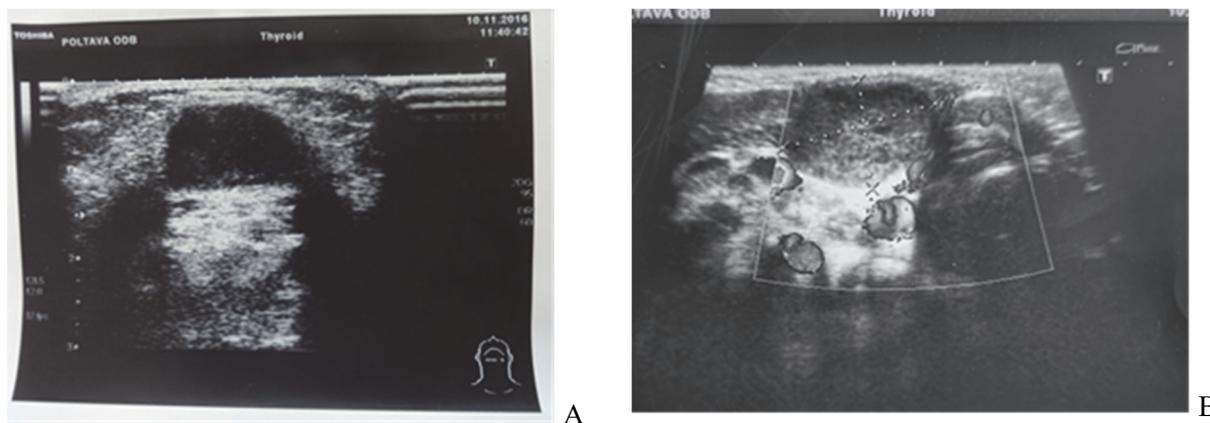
Ultrasound images of patients with median neck cysts (A, B).
